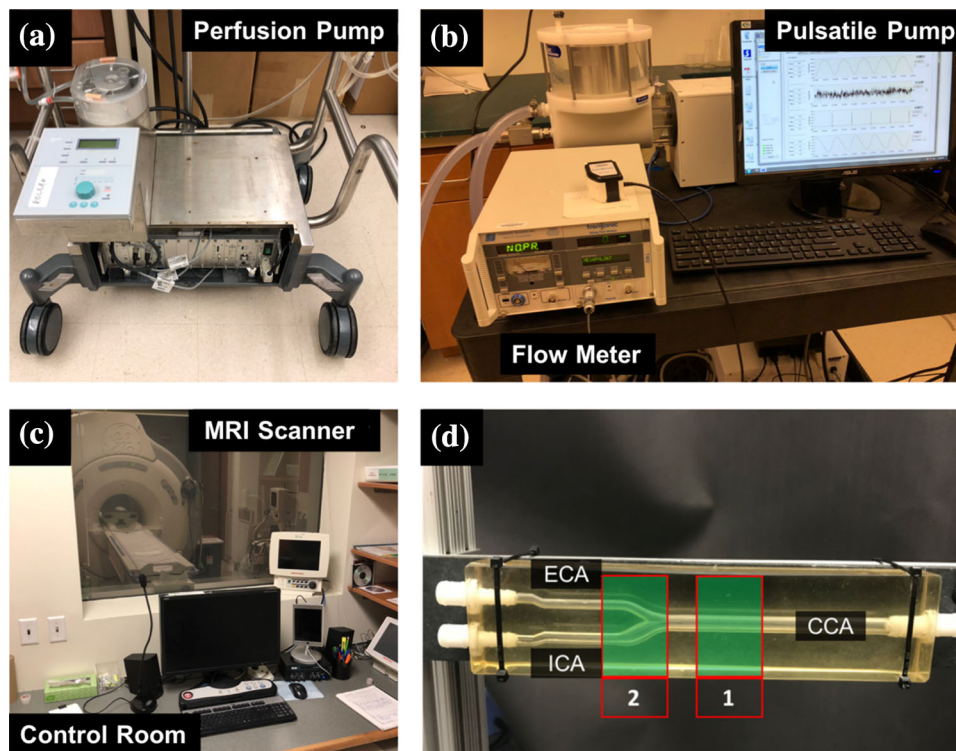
(a) Perfusion pump for continuous flow experiments. (b) Pulsatile pump, including the conditioning head on the top left. (c) Control room for the 4D Flow MRI experiments. The room where the scanner is located can be seen through the window. Long tubing was directed through the dividing wall, connecting the pump to the silicone model on the MRI scanner. (d) Silicone *in vitro* model of the carotid artery bifurcation. Data were acquired at the [1] CCA and [2] bifurcation for comparison between velocity measurement techniques.
